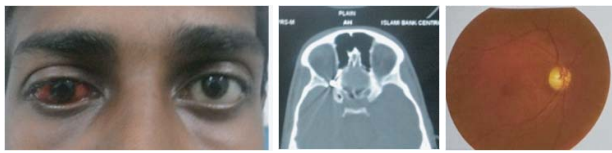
Direct Traumatic Optic neuropathy A. The CT scan of the orbit shows a round metallic foreign body (pellet) is impacted in the most posterior part of the right orbit. B. The patient's anterior segment was subconjunctival hemorrhage and a conjunctival entry wound at temporal aspect. Posterior segment shows normal study. C. The color fundus photograph shows the pallor of the optic disc after 6 weeks of injury. The patient's visual acuity was no-perception of light, but optic disc showed normal initially.
